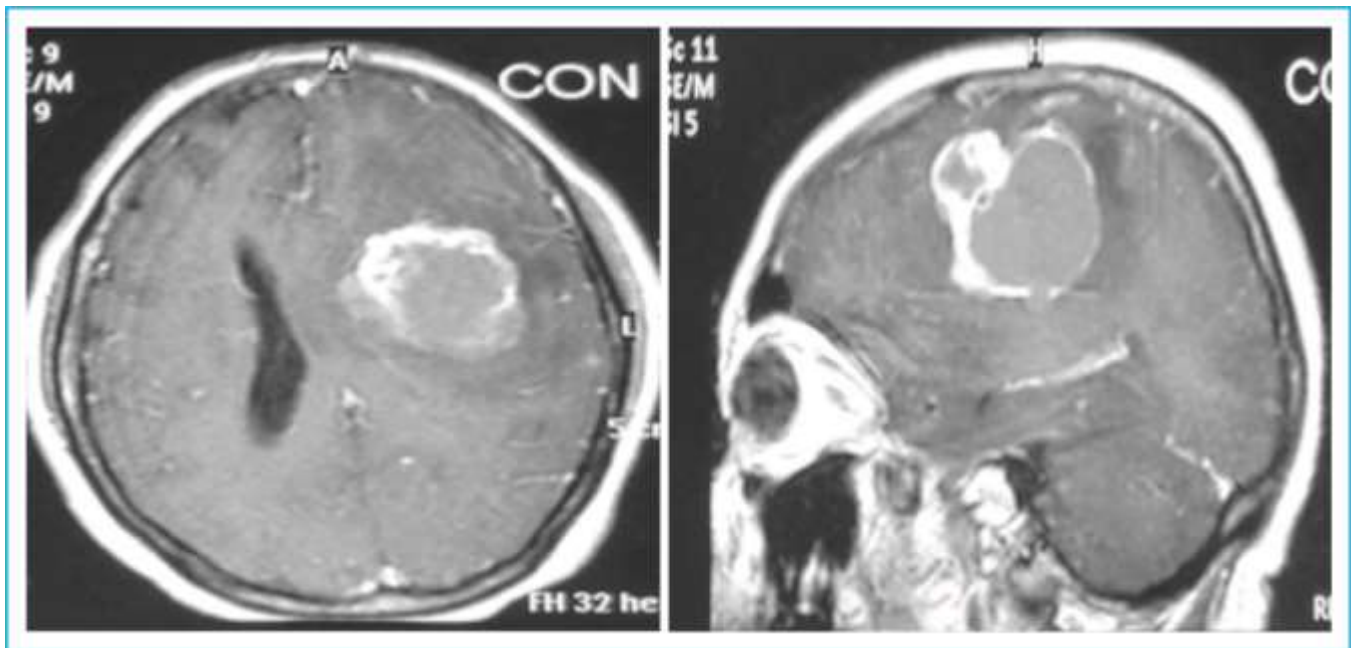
MRI brain with contrast axial and sagittal images showing peripheral enhancing tumor.
